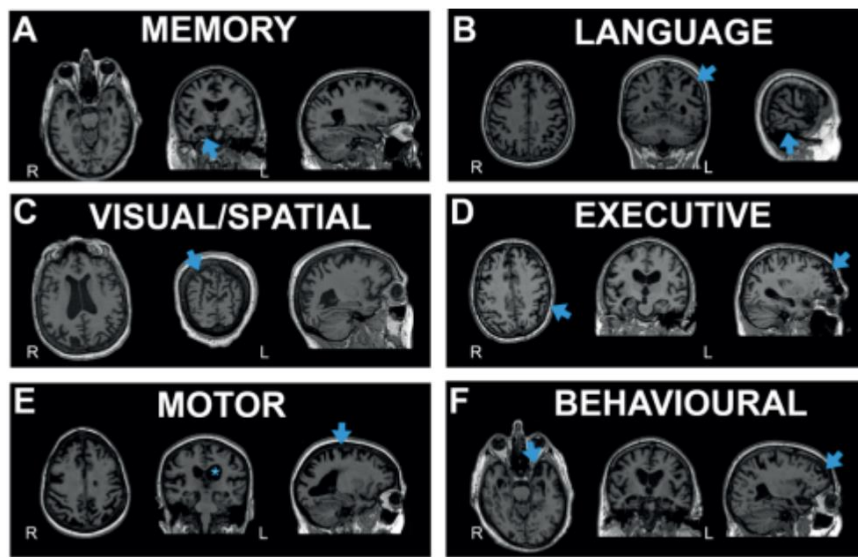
MRI across AD phenotypes; blue arrows indicate atrophy regions [1].
